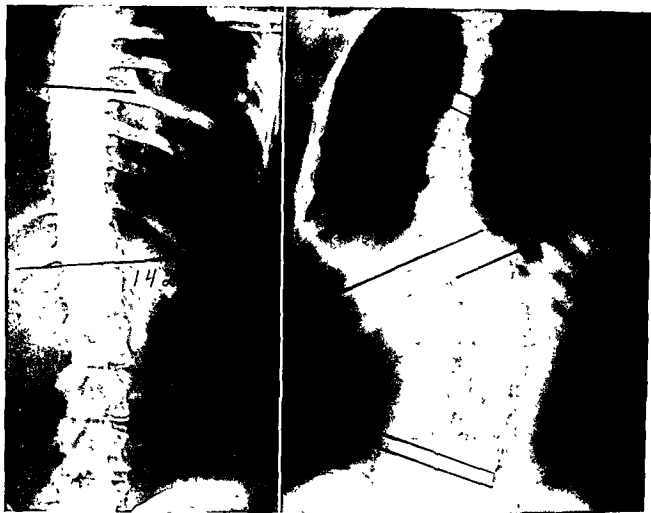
(Left) Case 1. Roentgenograms taken 25 months apart and superimposed to demonstrate absence of growth at the D8-D12 segment. On the earlier roentgenogram the patient was 13 years and 10 months old, but her skeletal age was 16 years. The lumbar vertebrae do not superimpose due to the mobility of the lumbar spine and distortion. (Right) Case 2. Roentgenograms taken 22 months apart and superimposed demonstrate marked growth at the D8-D12 segment. On the earlier roentgenogram the patient was 15 years and 3 months old, but her skeletal age was only 13 years and 6 months. Note that although the iliac apophyses are complete (the one on the right corresponds to the earlier roentgenogram and that visualized on the left to the later), the patient grew 10 mm at the D8-D12 segment. There are a right dorsal (D6-D11) curve of 50° and a left lumbar (D11-L4) curve of 56° , which have maintained their limits and values in spite of marked growth.
